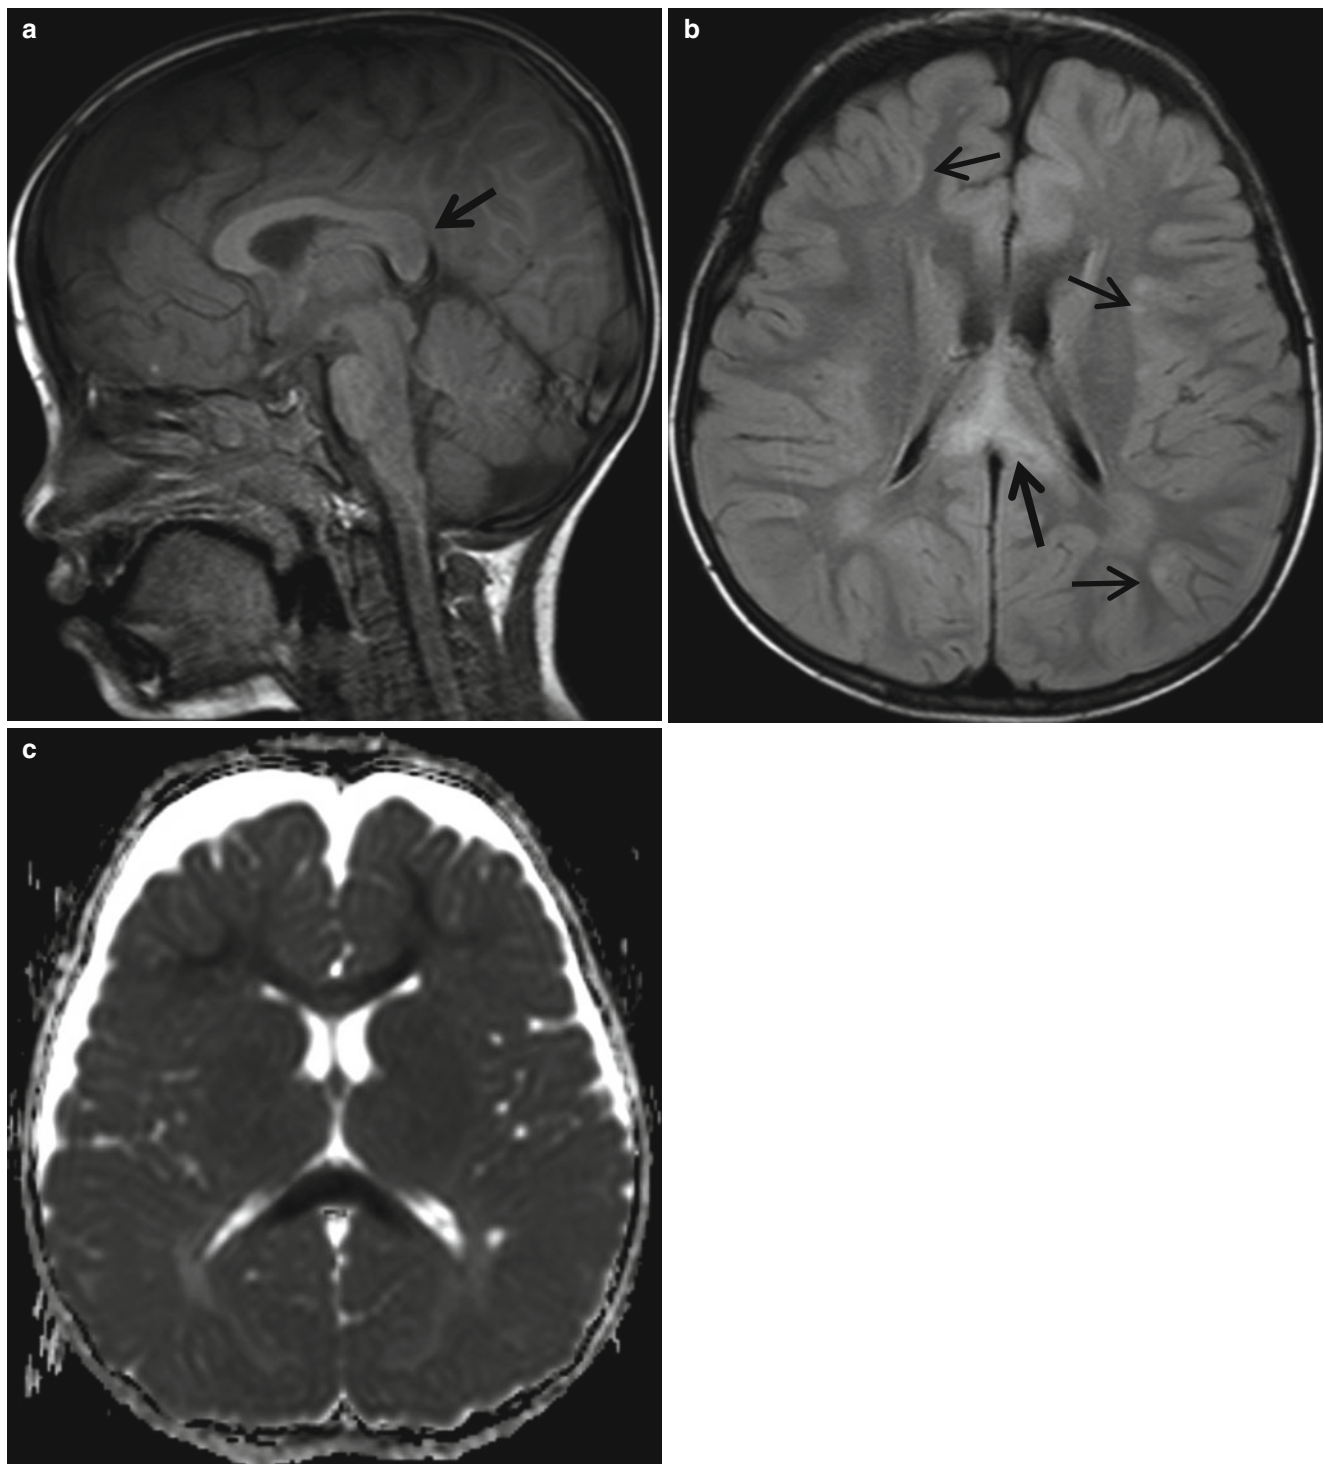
Axonal injury. (a) T1-weighted sagittal image shows hypointense lesion at the splenium (*arrow*). (b) FLAIR image shows multiple high-intensity lesions at the splenium of the corpus callosum
